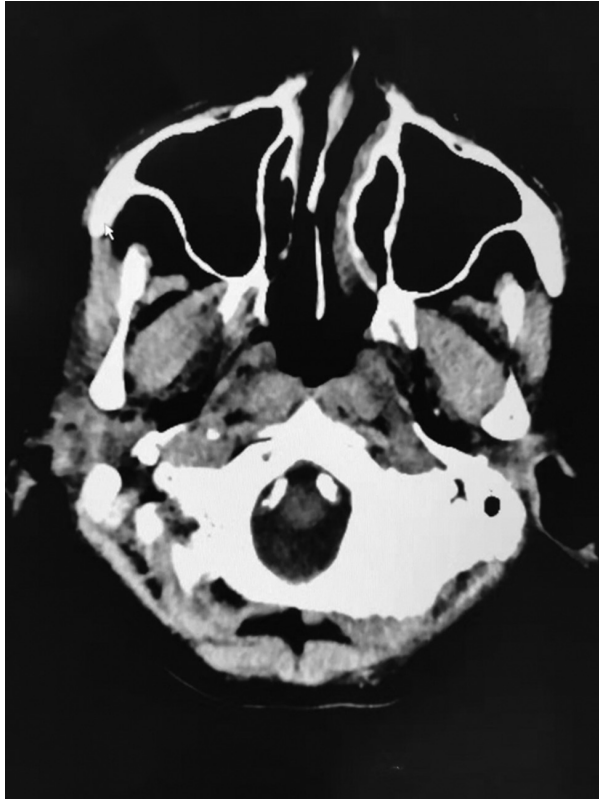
The non-contrast CT of a patient with bilateral intracranial vertebral artery occlusion revealed the severe calcification of bilateral vertebral arteries.
